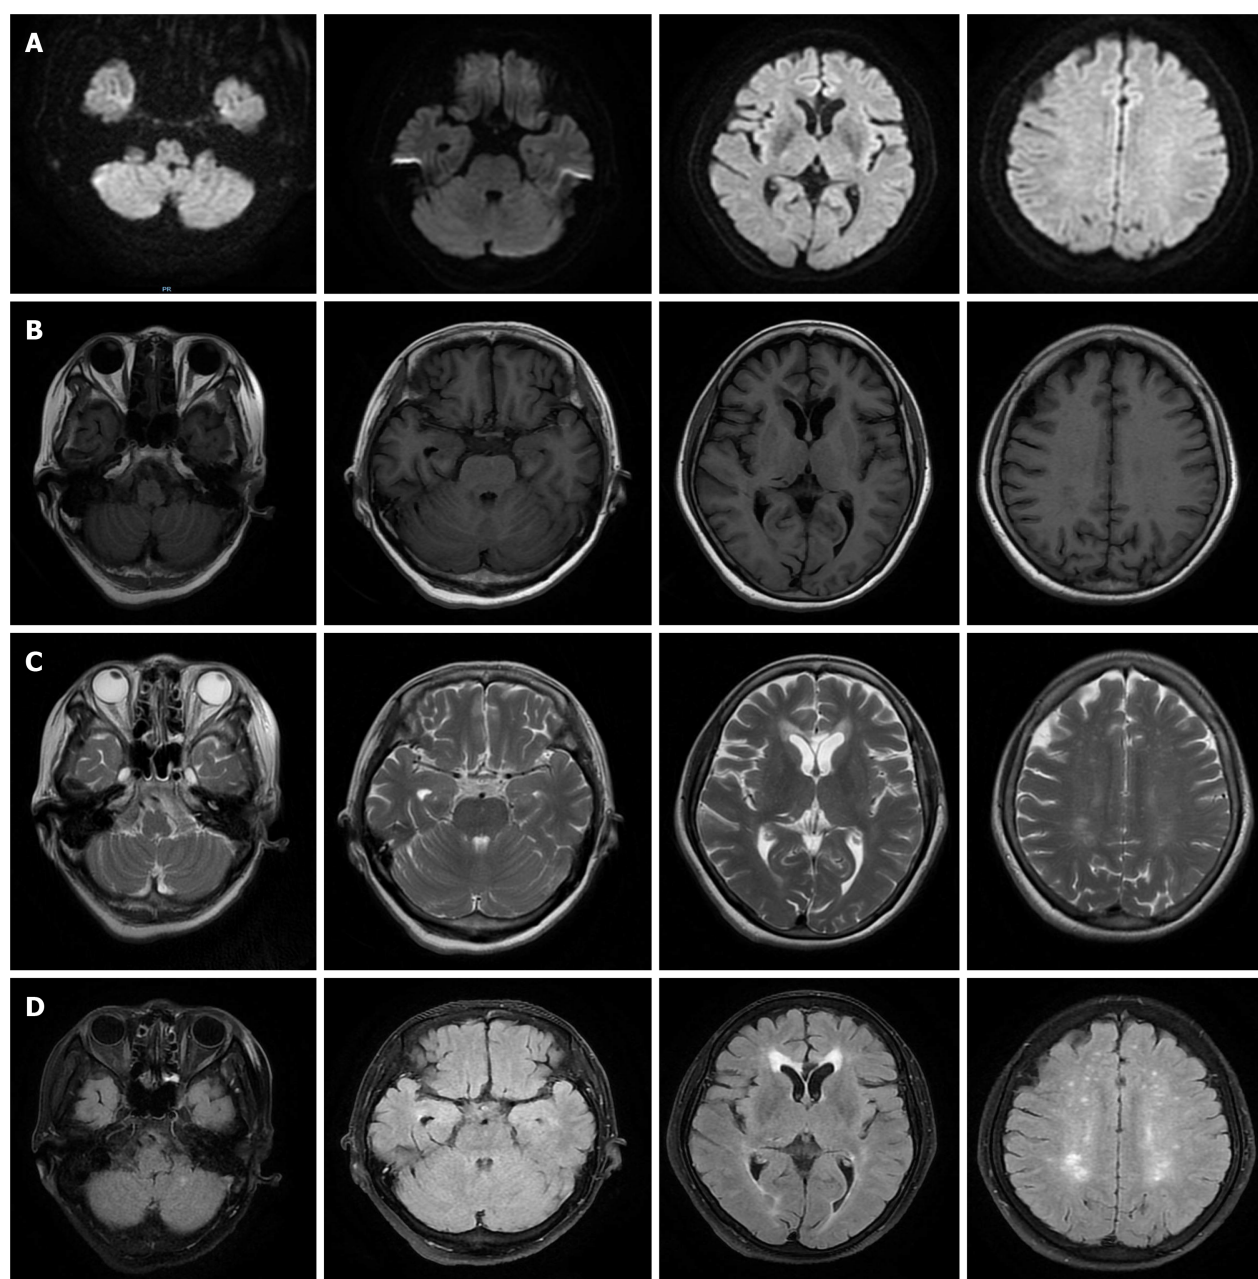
Magnetic resonance imaging showed multiple sub-frontal and parietal cortex, semi-oval centers, and lateral ventricles with multiple spot-like and sheet-like lesions, equal signal on diffusion-weighted imaging, slightly longer signal on T1, longer signal on T2, and partially high signal on flair. A: Diffusion-weighted imaging; B: T1; C: T2; D: Flair.
